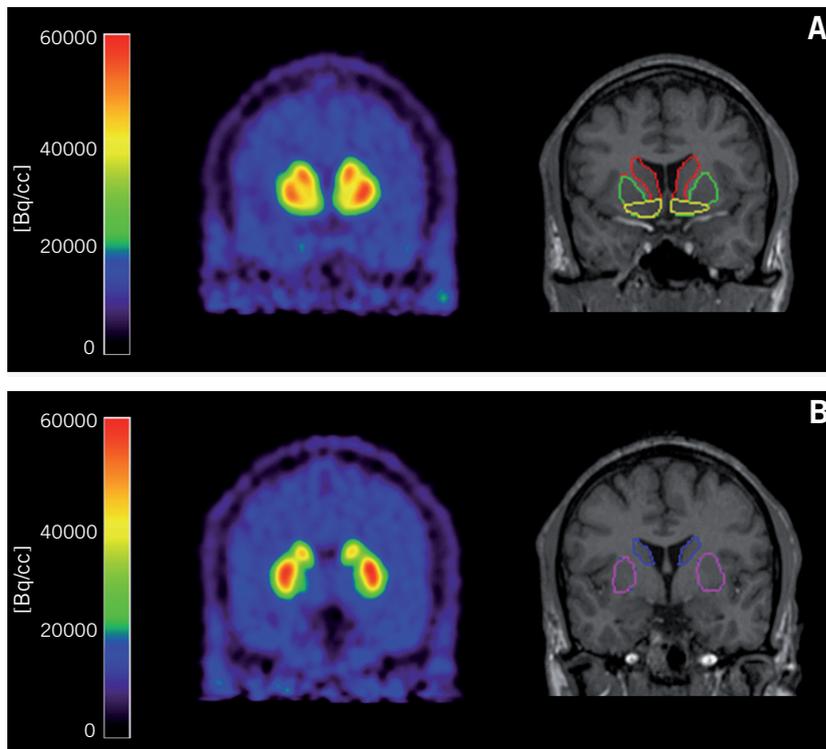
Coronal slices of (left) PET [¹¹C]raclopride and (right) co-registered MRI scans at the level of the striatum, (A) anterior and (B) posterior to the AC-plane. Striatal subregions are indicated on the MRI scans: ventral striatum (yellow), precommissural dorsal putamen (green), precommissural dorsal caudate (red), postcommissural putamen (purple) and postcommissural caudate (blue).
